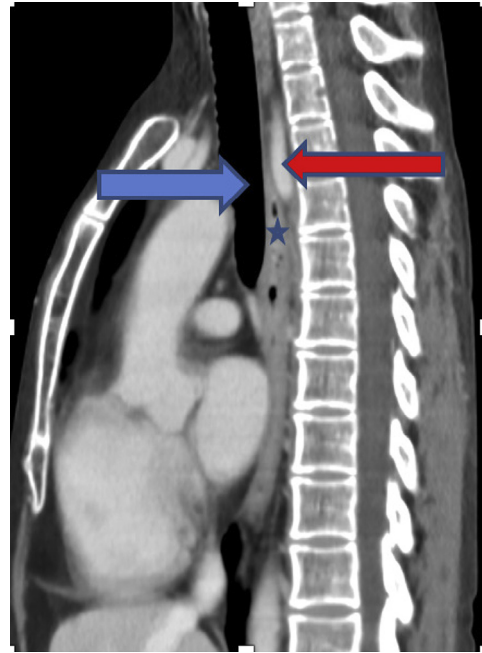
Computed tomography (coronal reformation, maximum intensity projection) shows an aberrant right subclavian artery (arrow) that originates from the proximal portion of the descending aorta and crosses the central line behind the esophagus (star) to provide the right upper limb.
